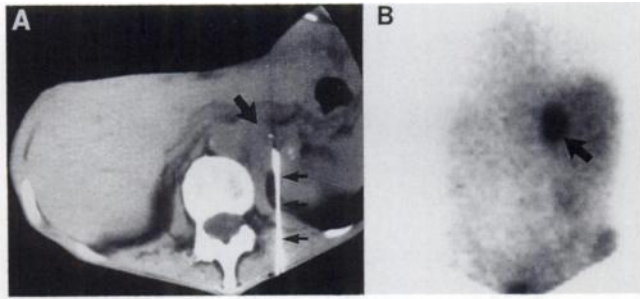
(A) CT-guided needle (small arrows) biopsy of a 5 cm left adrenal mass (large arrow) from metastatic lung carcinoma (B) Posterior NP-59 scintiscan identifies the right adrenal (arrow), no left adrenal cortical activity is seen.
